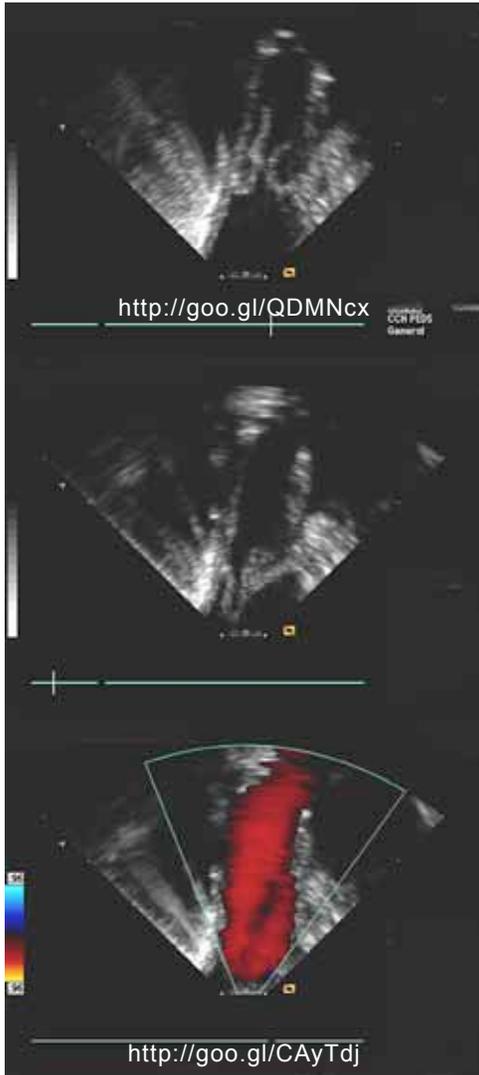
Baseline intracardiac echocardiography. Top image: Leaflets of the Core Matrix conduit opening into the conduit (systole). Middle image: The leaflets prolapsing into the right ventricular outflow tract. Bottom image: Free pulmonary insufficiency.
